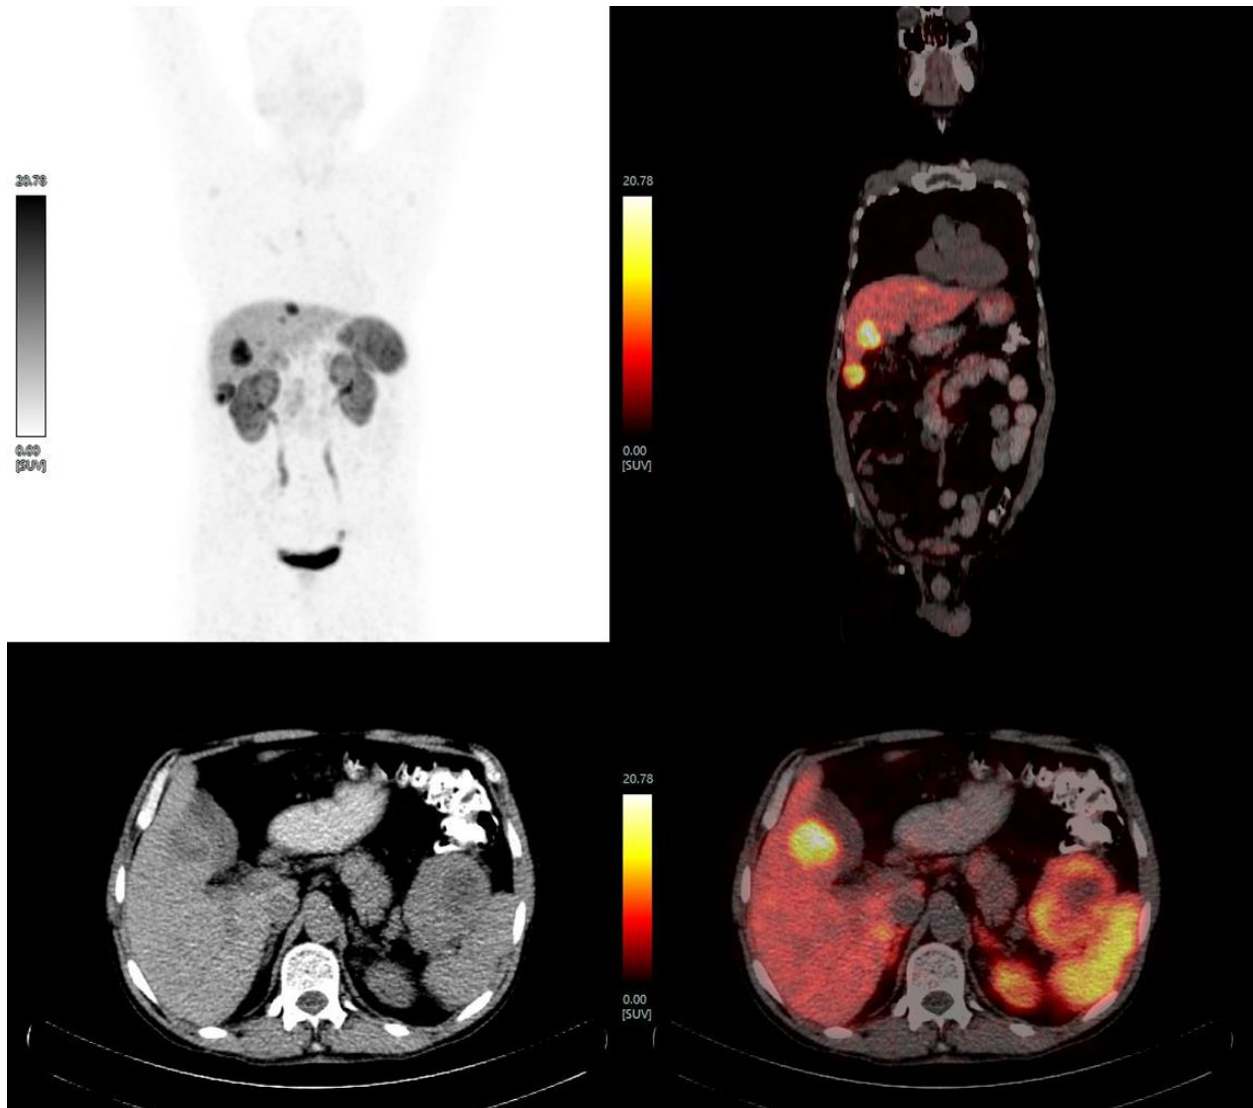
Baseline ^{68}Ga -DOTATATE PET/CT (MIP, fused coronal, transaxial slices) showing SSTR expressing multiple hepatic metastases (Liver segment V lesion)
